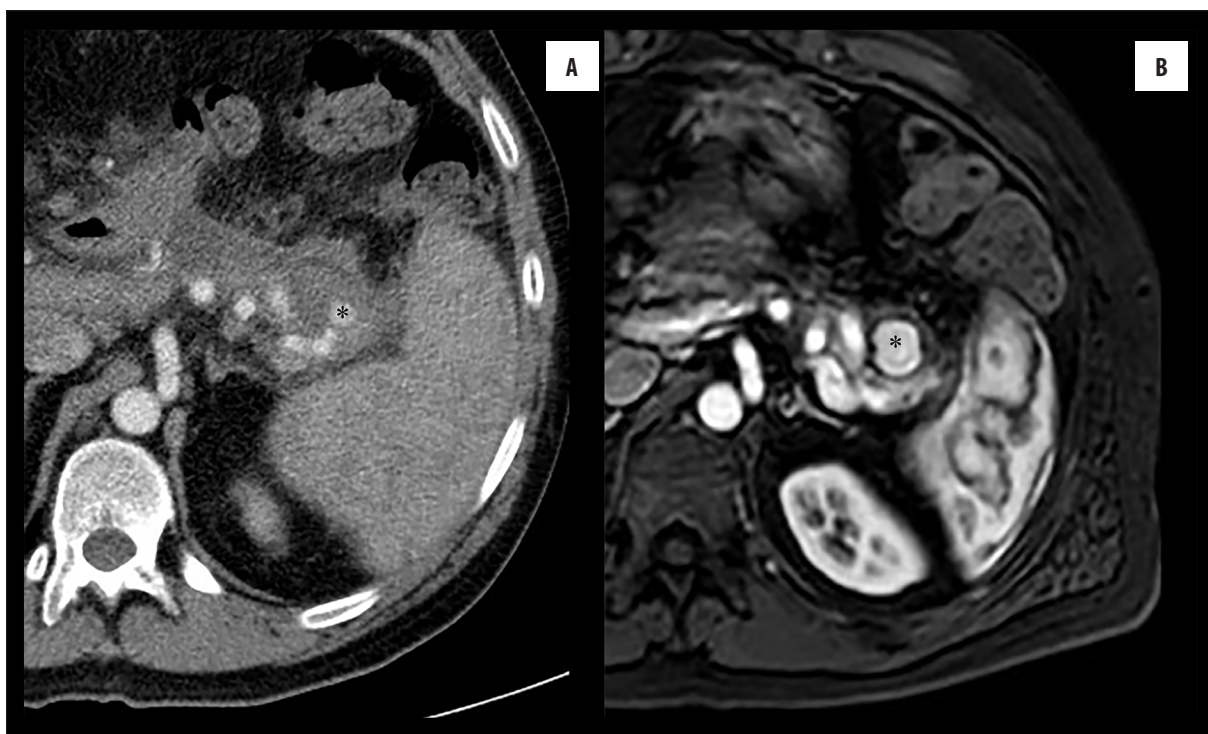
(A) Contrast-enhanced CT scan demonstrates a pseudoaneurysm (asterisk) of the pancreatic tail of 1.2 cm. (B) Contrast-enhanced MRI performed after one month shows an increase in the size of the pseudoaneurysmatic sac.
